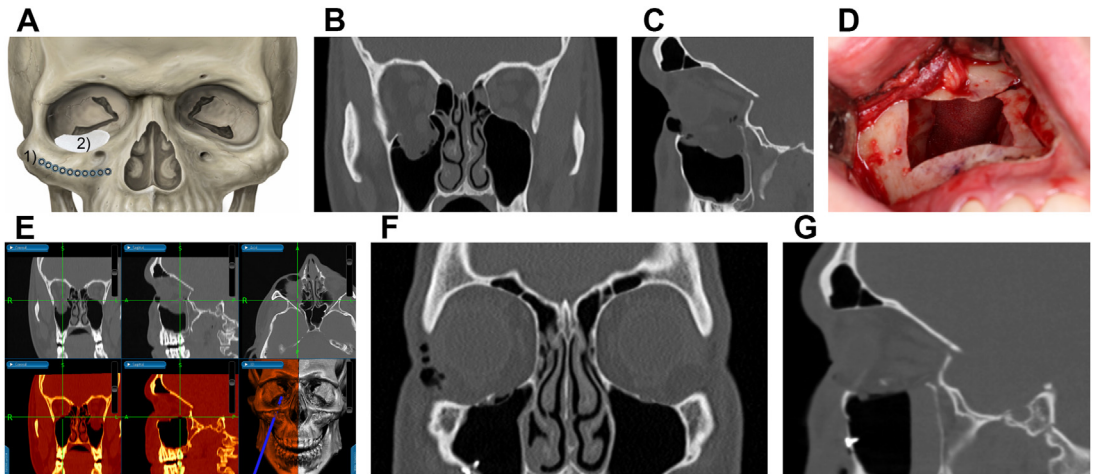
Case of an isolated orbital floor fracture reconstructed through a transantral approach. (A) An antral window is removed from the anterior maxilla and replaced with fixation after the orbital floor implant is appropriately positioned. CT (B) coronal and (C) sagittal views demonstrating blow-out fracture of the right orbital floor. (D) Large maxillary antrostomy used to approach the orbit. (E) Intraoperative navigation used to ensure safe posterior dissection along the floor defect. (F, G) Postoperative imaging demonstrating reduced orbital contents and good form of the replaced anterior maxilla.
